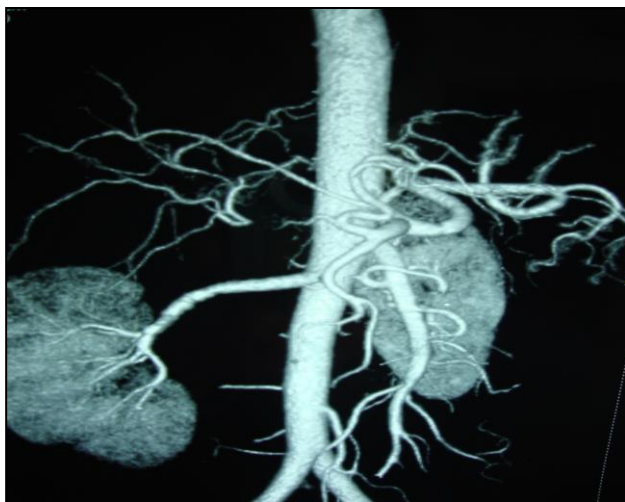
CT angiogram of right hepatic artery injury.
